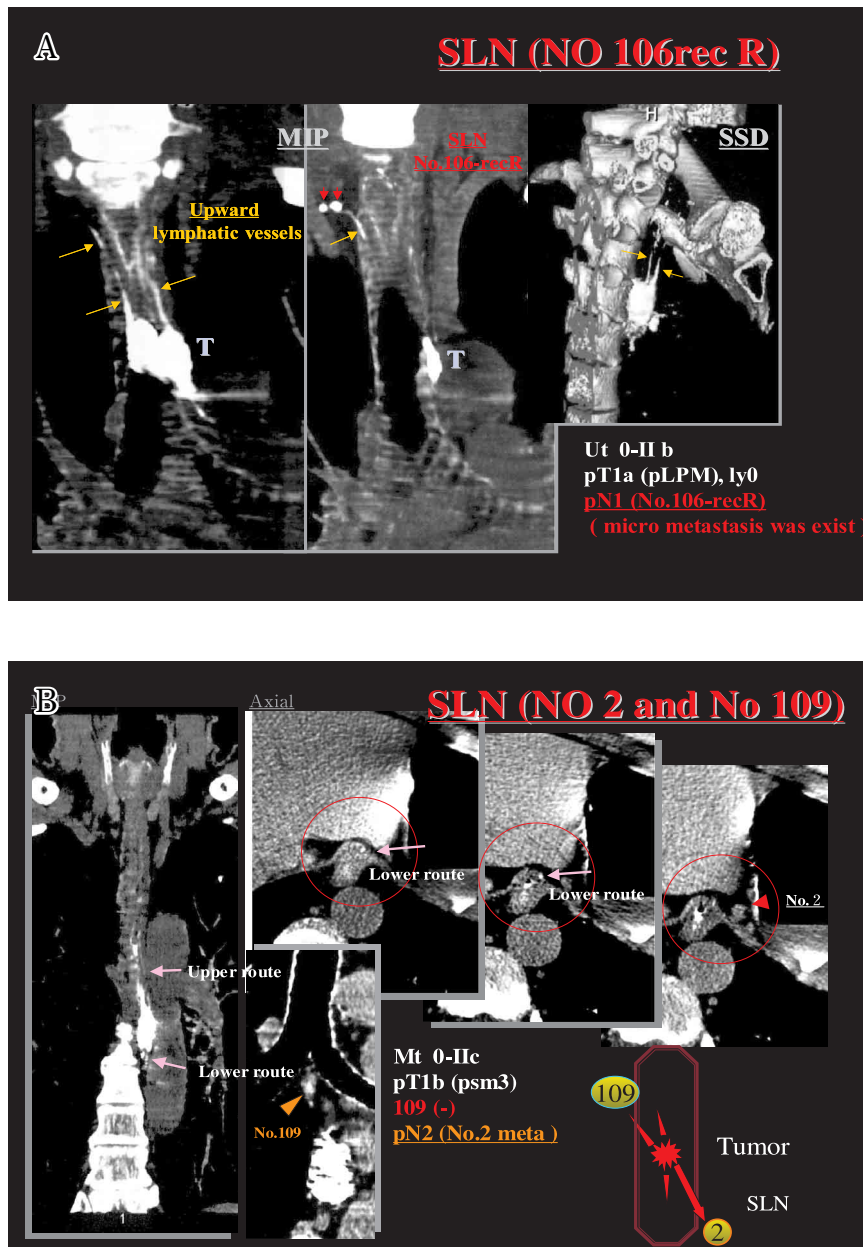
A B. 3D CT lymphography of esophageal cancer
